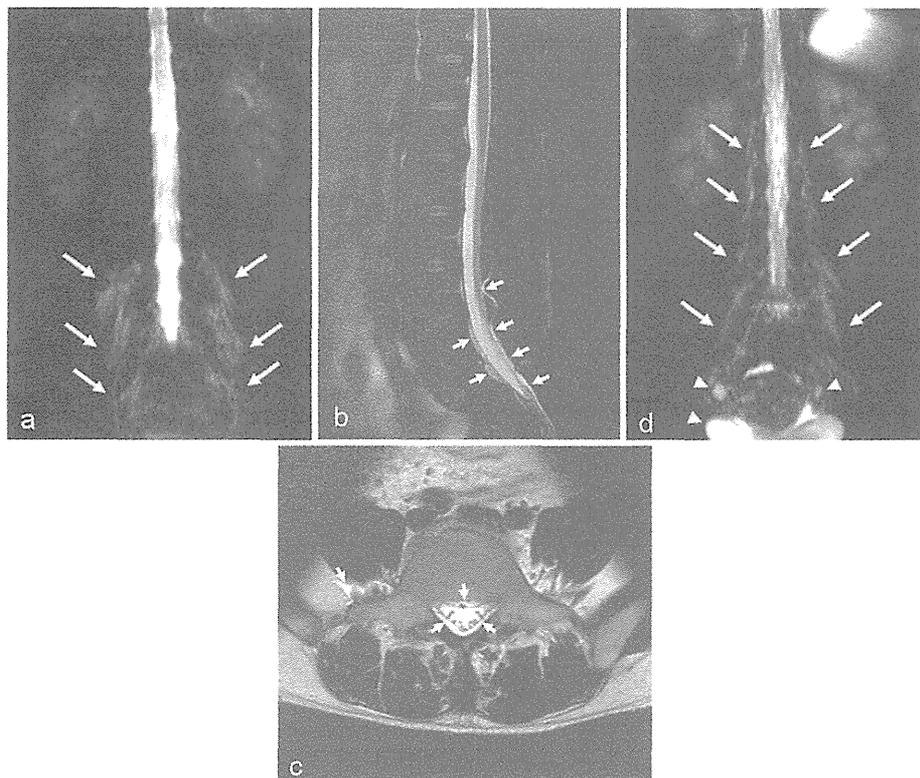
Representative magnetic resonance myelography (MRM) images of postpuncture cerebrospinal fluid (CSF) leakage. 2D MRM images were performed about 28 and 6 hours after the lumbar punctures in a 44-year-old male with chronic inflammatory demyelinating polyneuropathy (patient A) and a 42-year-old female with multiple sclerosis (patient B), respectively. Bilateral fluid collection around the nerve roots and paraspinal area (a, d) were depicted on 2D MRM images (arrows). Additionally, sagittal fat-suppressed T2-weighted (b) and axial T2-weighted (c) images of patient A revealed abnormal epidural and paraspinal fluid collections (arrowheads). In spite of such leakage, patient A was asymptomatic. However, patient B complained of an orthostatic headache that had persisted for six days. Arrowheads indicate fluid accumulation that was unrelated to CSF leakage (e.g., the bladder and ovarian cysts).
